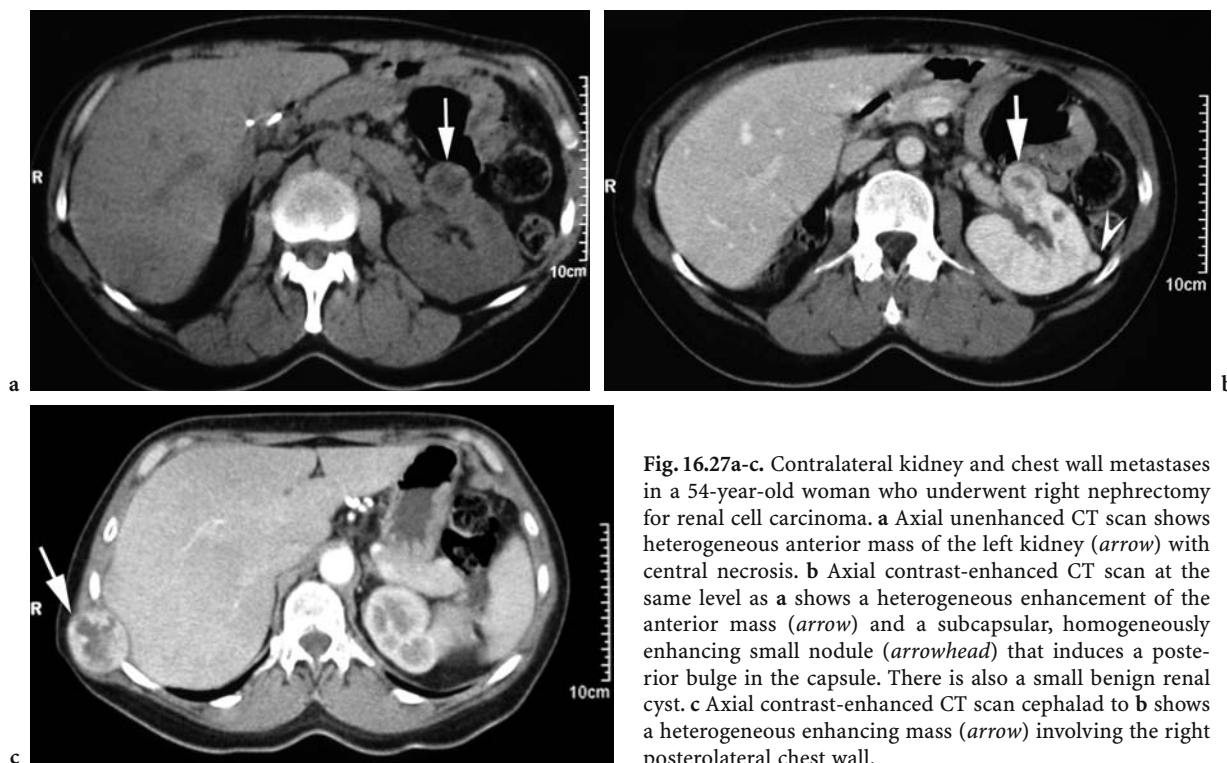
Contralateral kidney and chest wall metastases in a 54-year-old woman who underwent right nephrectomy for renal cell carcinoma. a Axial unenhanced CT scan shows heterogeneous anterior mass of the left kidney (*arrow*) with central necrosis. b Axial contrast-enhanced CT scan at the same level as a shows a heterogeneous enhancement of the anterior mass (*arrow*) and a subcapsular, homogeneously enhancing small nodule (*arrowhead*) that induces a posterior bulge in the capsule. There is also a small benign renal cyst. c Axial contrast-enhanced CT scan cephalad to b shows a heterogeneous enhancing mass (*arrow*) involving the right posterolateral chest wall.
